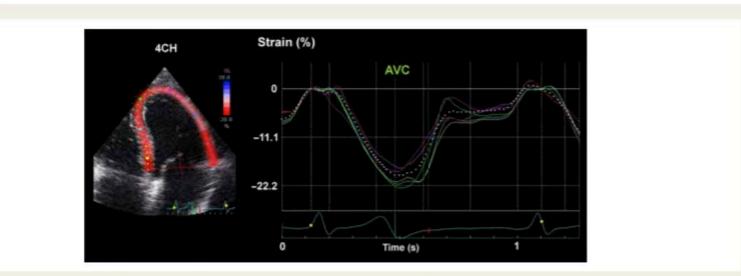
Figure I Segmental strains in apical four-chamber view, showing normal contractions. The color of each trace corresponds to anatomical points on the 2-D color image to the left. The white dotted line represents average strain.
